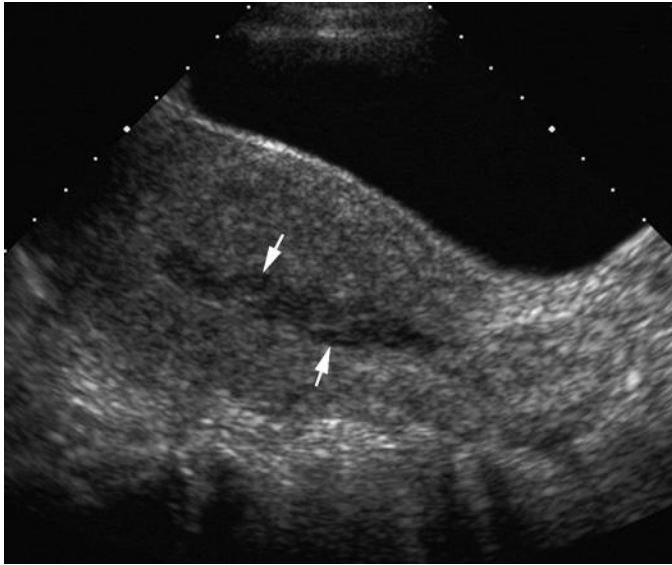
Transabdominal sagittal sonogram in a patient 3 days postpartum presenting with more than expected residual postpartum bleeding. Fluid and tissue (arrows) are seen in the endometrial cavity, consistent with hemorrhage. There was no evidence of retained products of conception.
